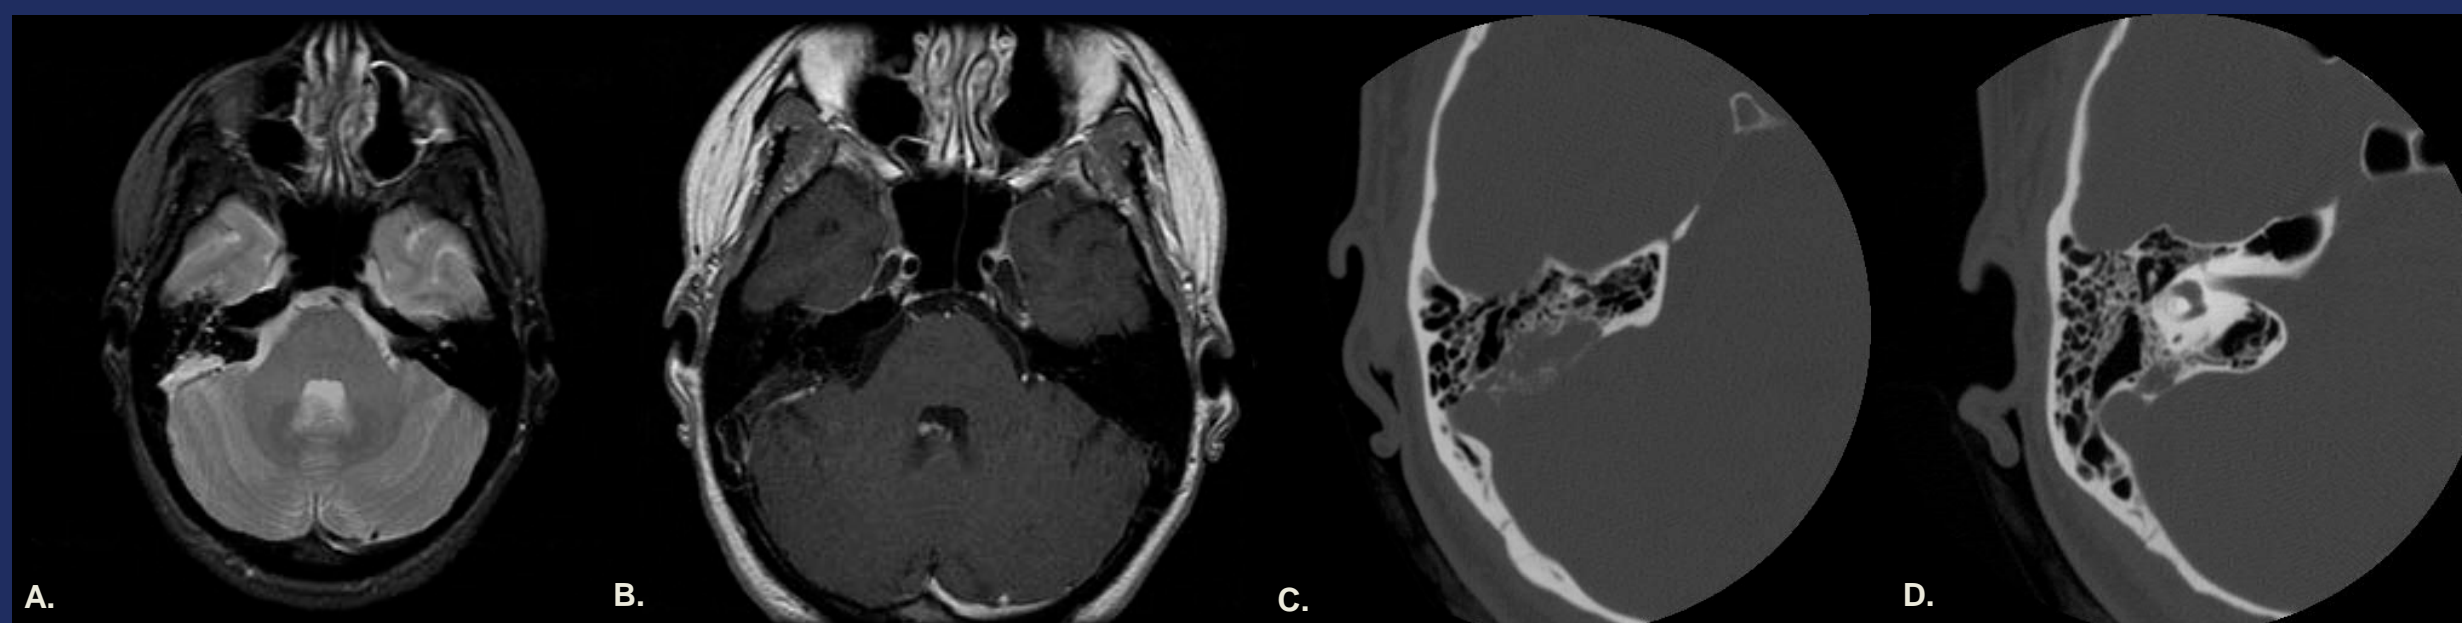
Case #2 of a surgically-confirmed posterior temporal bone arachnoid granulation. (A) Axial T2-weighted MRI depicts a right posterior cranial fossa lesion in the area of the endolymphatic sac. Signal is isointense to CSF. (B) Axial T1 post-contrast MRI demonstrates faint dural rim enhancement but no suspicious solid or nodular enhancement. (C) High-resolution temporal bone CT shows a focal lesion centered in the posterior right petrous temporal bone with geographic cortical erosion extending into the adjacent mastoid air cells. (D) The mass is centered well above the level of the vestibular aqueduct, which argues against endolymphatic sac tumor.
